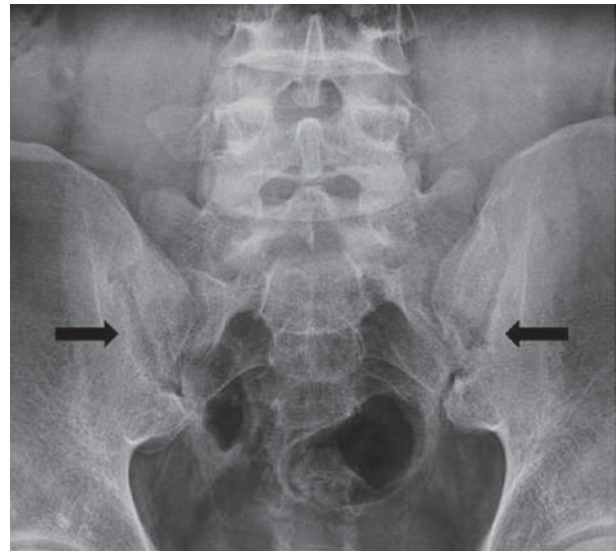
Radiograph of the pelvis: Such pelvic radiography reveals bilateral grade 2 sacroiliitis with erosions, bony sclerosis and joint-width irregularities (black arrows).
